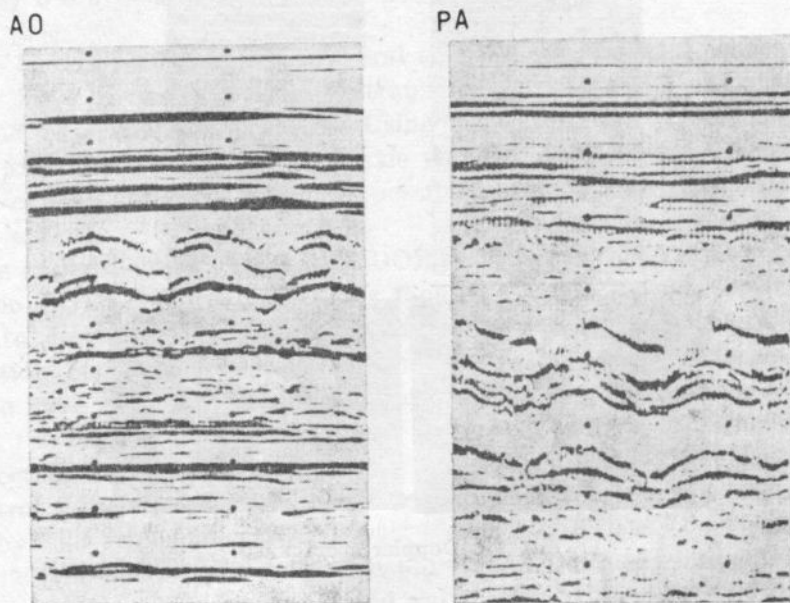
An echocardiogram pattern of the aortic and pulmonary valves
